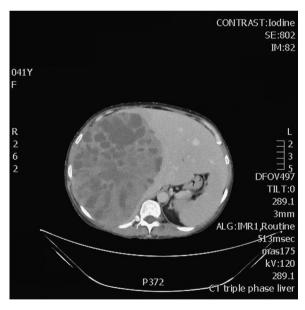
Transverse Computed Tomography scan. The figure shows a cross-sectional scan of the mass occupying the right lobe of the liver.
